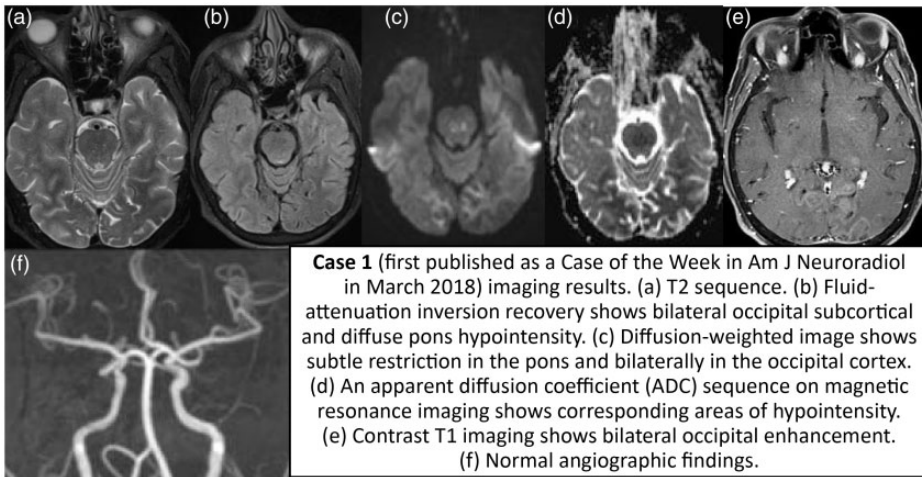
Case 1 (first published as a Case of the Week in *Am J Neuroradiol* in March 2018) imaging results. (a) T2 sequence. (b) Fluid-attenuation inversion recovery shows bilateral occipital subcortical and diffuse pons hypointensity. (c) Diffusion-weighted image shows subtle restriction in the pons and bilaterally in the occipital cortex. (d) An apparent diffusion coefficient (ADC) sequence on magnetic resonance imaging shows corresponding areas of hypointensity. (e) Contrast T1 imaging shows bilateral occipital enhancement. (f) Normal angiographic findings.
